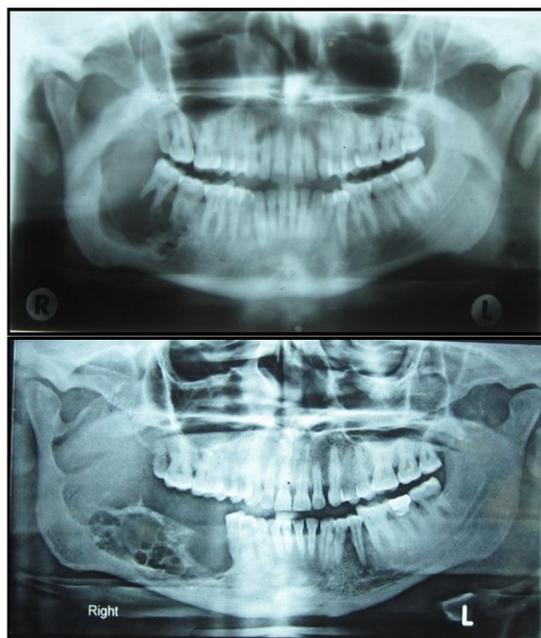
Panoramic radiograph in the year 2004
